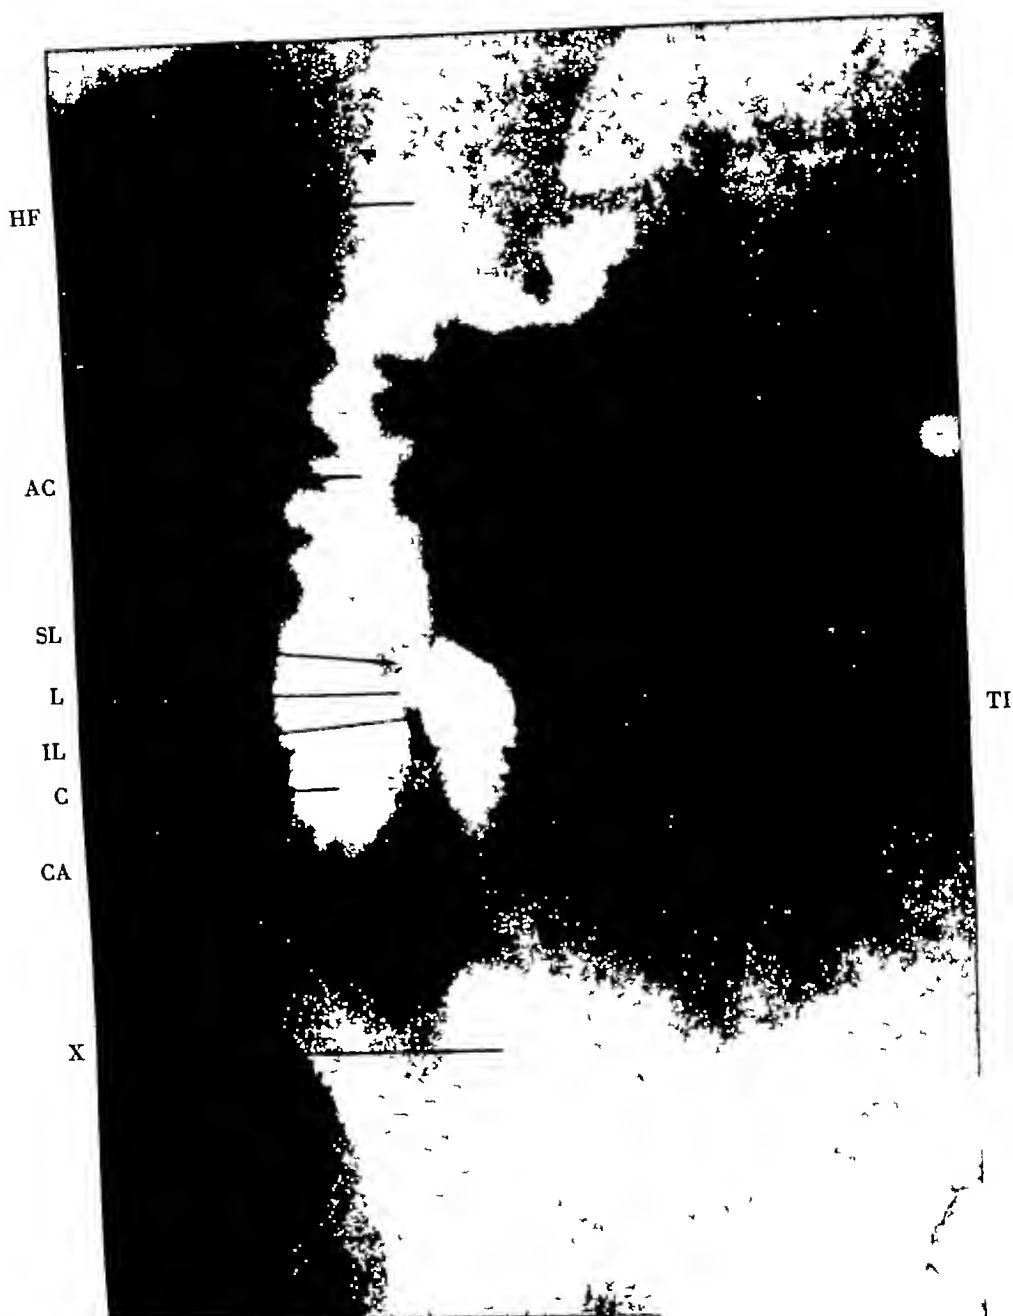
The ileocecal valve as shown roentgenographically immediately after the evacuation of a barium enema. The valve is open. L—Lumen of the valve. SL—Superior lip of the valve. IL—Inferior lip of the valve. TI—Terminal ileum. C—Cecum. AC—Ascending colon. HF—Hepatic flexure. CA—Area of contraction in the terminal ileum. X—Dilated coil of lower ileum proximal to the area of contraction.
